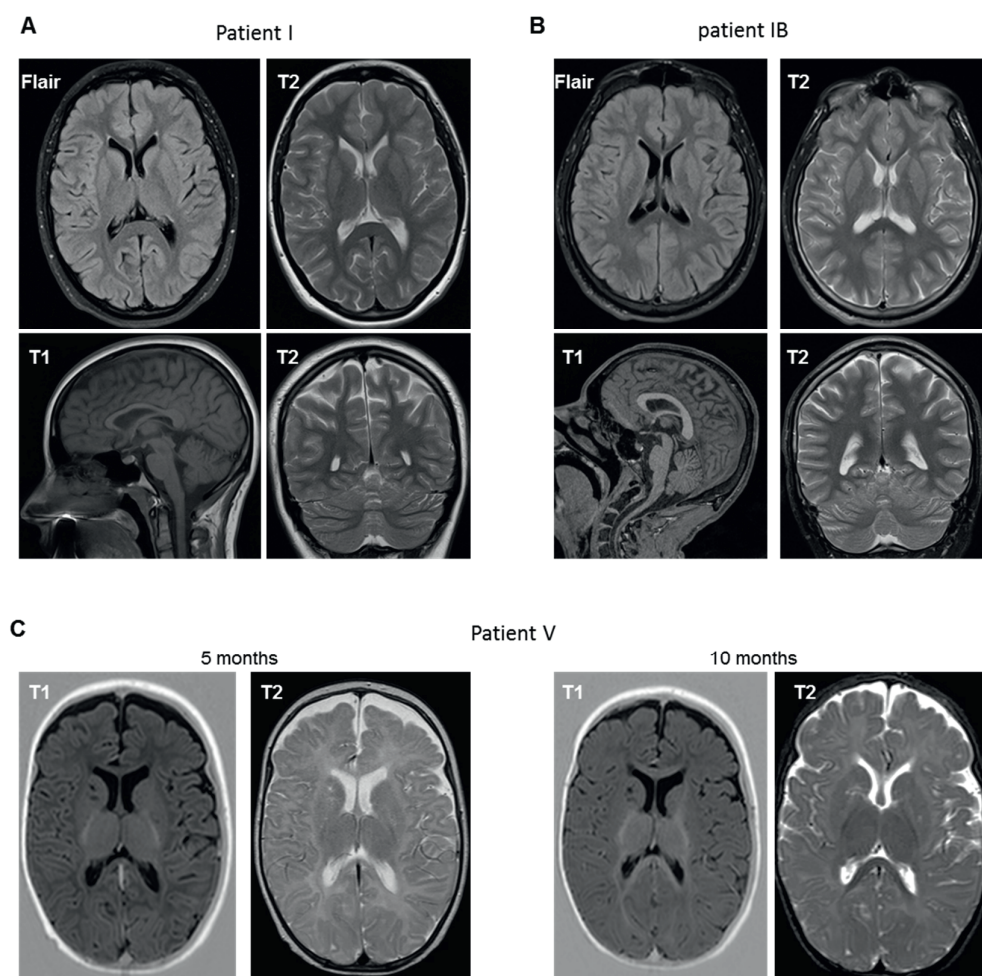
MRI studies in patient P1 (female), her affected brother (patient P1B) and patient P5 (male). (A) Flair-, T1- and T2-weighted MRI of the brain of patient P1 performed at the age of 21 years showing mild cortical atrophy without signs of leukodystrophy. (B) Flair-, T1- and T2-weighted MRI of the brain of the brother of patient P1 (patient IB) performed at the age of 25 years, showing signs of mild cortical atrophy without obvious signs of leukodystrophy. (C) T1- and T2-weighted MRI of the brain of patient P5 at the age of 5 months (left) and 10 months (right) showing a global delay in myelination which is particularly apparent in the frontal white matter, anterior limb of the internal capsule and periventricular white matter. Myelination appears progressive over time. The applied MRI sequences are indicated in each image.
